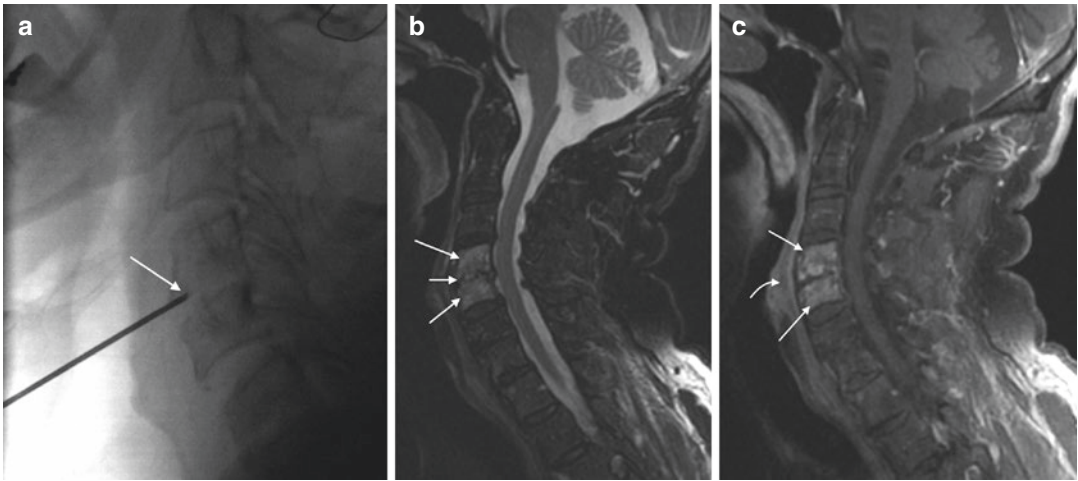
A 73-year-old male with neck pain. Lateral fluoroscopic image (a) obtained during C4–C5 anesthetic injection (arrow). Patient’s pain improved, and a follow-up MRI for evaluation of prostate cancer shows diffuse-increased signal within the vertebral bodies (large arrows) and C4–C5 disk (small arrow) on the T2 sagittal
